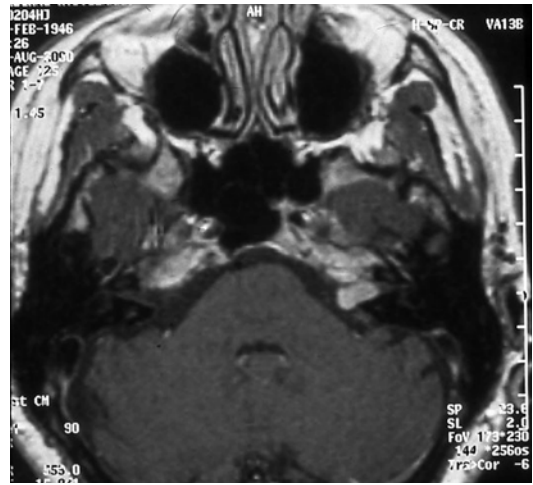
MR image of an acoustic neuroma on the right side leading to facial nerve paresis
